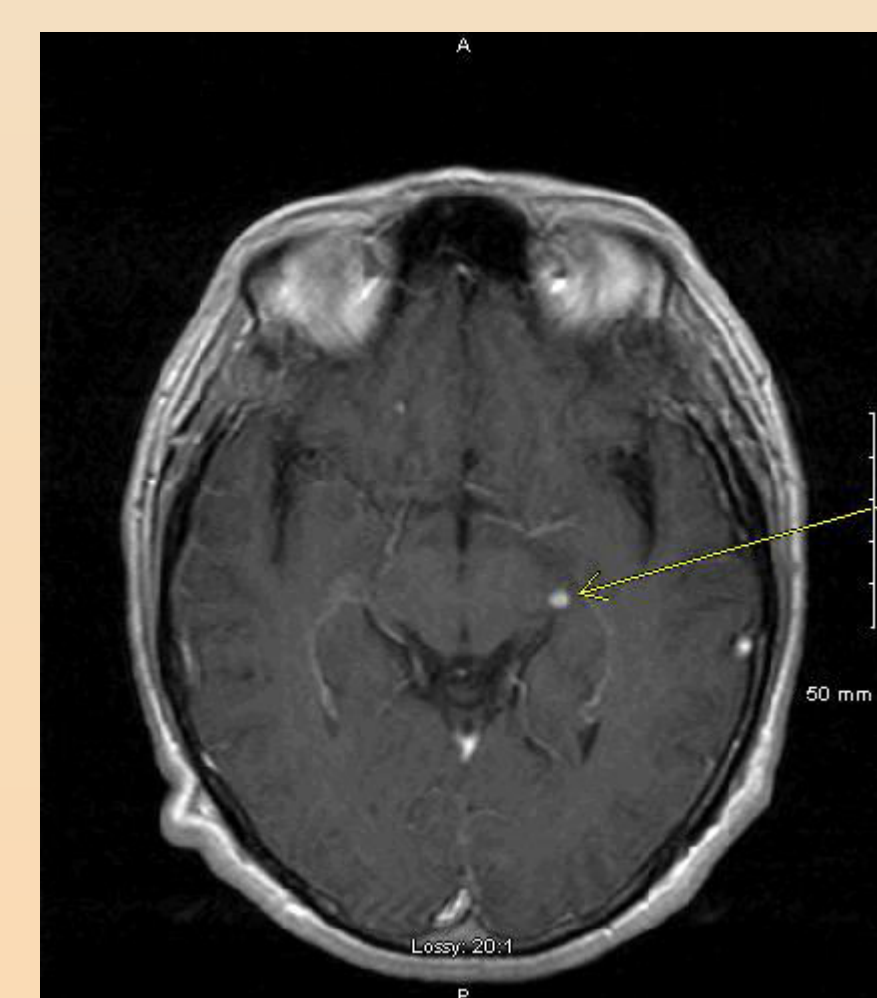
MRI T1 Axial + GAD showing lesion to left geniculate body. 2014
